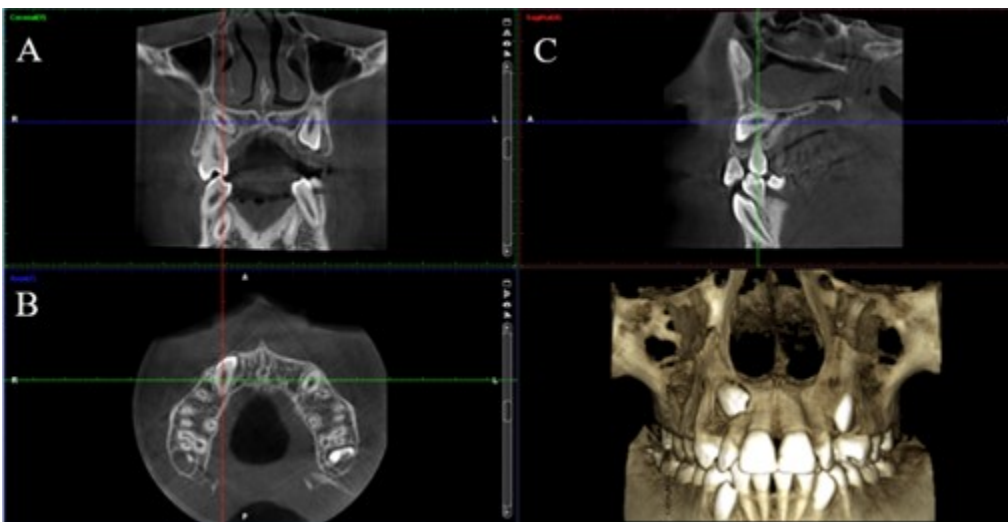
The three-dimensional reconstructed image obtained from raw CBCT data; (A) Coronal view, (B) Axial view, and (C) Sagittal view.
